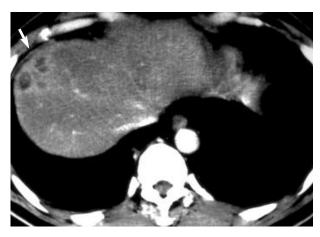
Contrast-enhanced CT of the liver shows a cluster of rimenhancing, small cysts at the subcapsular area of the segment VII. Note mild enhancement of the hepatic capsule and pleural thickening (arrow) adjacent to the hepatic lesion.
